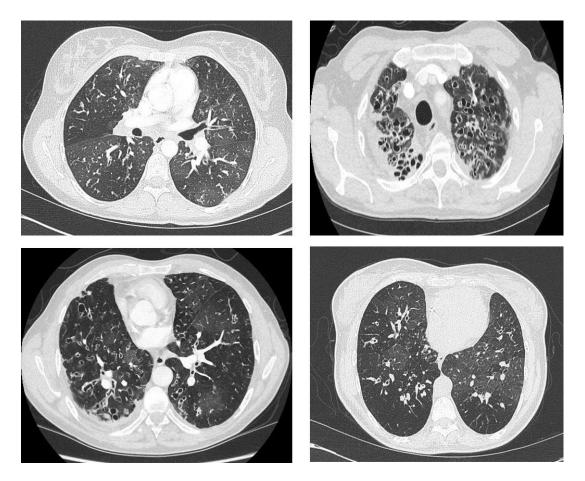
CT scan of patients with CF. A combination of several structural abnormalities (bronchiectasis, air trapping, mucus plugging and atelectasis) and areas of relatively spared parenchyma can be observed. Courtesy of the Leeds Adult CF Centre.
